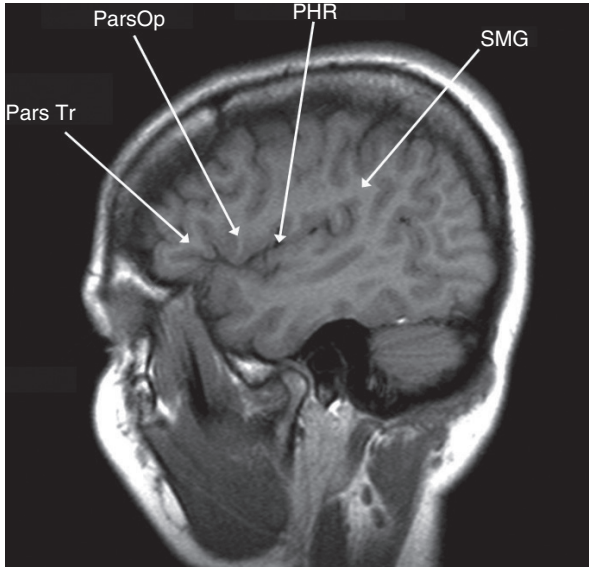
Lateral sagittal T1-weighted MRI scans. Pars triangularis (Pars Tr), pars opercularis (Pars Op), posterior horizontal ramus of the sylvian fissure (PHR), and supramarginal gyrus (SMG). Subcentral gyrus (SCG), precentral gyrus (PCG), central sulcus (CS), postcentral gyrus (PoCG), supramarginal gyrus (SMG), angular gyrus (AG), and superior temporal sulcus (STS).
